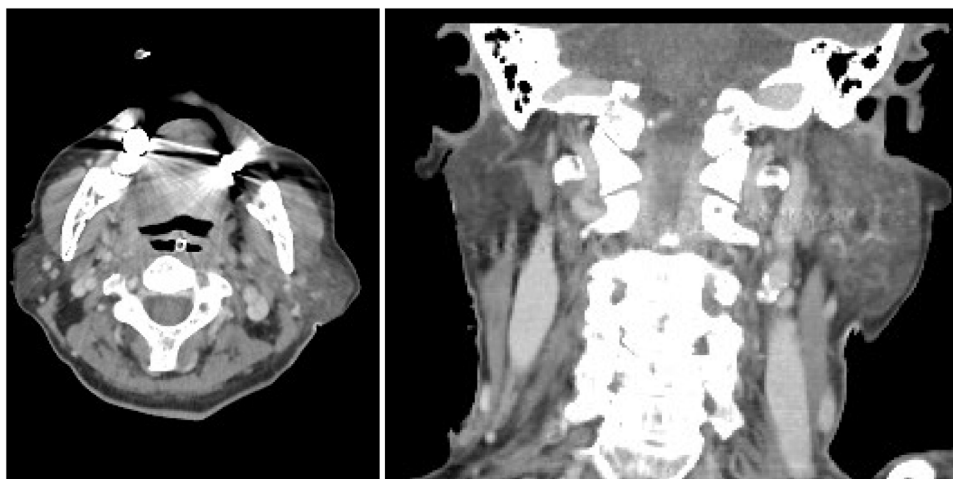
Computed tomography with contrast showing left parotid inflammation and swelling without obvious airway compression.
